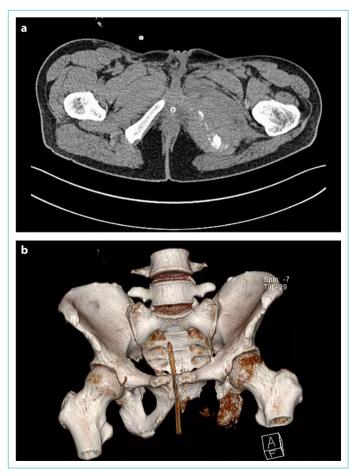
CT. Tumor lesion in the left ischium and pubis for the second relapse. (a) Cross sectional place. (b) Three-dimensional reconstruction.
